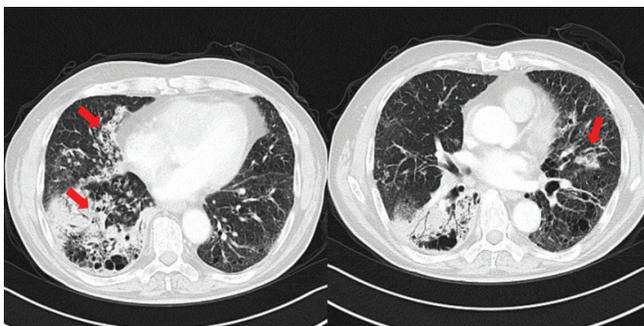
Axial plane contrast computed tomography scan 6 weeks after the first admission. In addition to previous consolidations in the lower right basal segment, newly developed air bronchograms and consolidation areas are observed in both lungs (red arrows).
